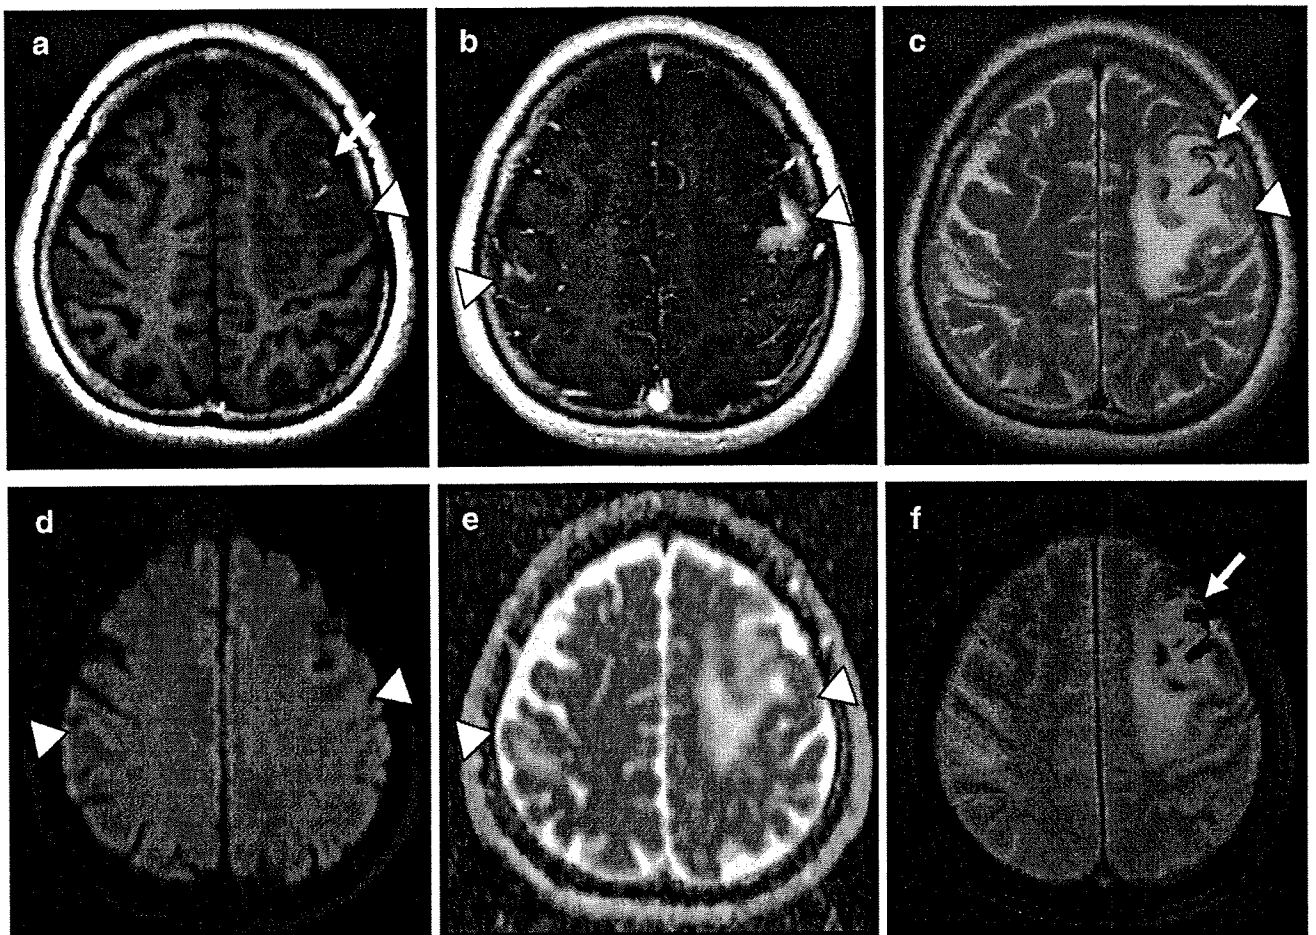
Cranial MRI of the lesions in left frontal lobe and right postcentral gyrus. The right side is shown on the left-hand side of each figure. a. Axial T1-weighted image demonstrates a hypointense area with focal hyperintensity (arrows) in the left frontal cortex and a small hypointense area in the right postcentral cortex. These lesions were surrounded by white matter edema that appeared homogeneously hypointense on T1-weighted images. b. Axial gadolinium-enhanced T1-weighted image shows focal enhancement of the cortical lesions in both hemispheres. c. Axial T2-weighted image shows slightly hyperintense area with focal hypointensity (arrows) in the left frontal cortex, and a slightly hyperintense area of the right postcentral gyrus. These lesions were surrounded by white matter edema that appeared homogeneously hyperintense on T2-weighted images. d, e. All lesions show high signal intensity on diffusion-weighted image (DWI) and slight low ADC values, while peripheral edema is slightly hypointense on DWI with elevated ADC values. f. Axial gradient-echo T2*-weighted image demonstrated hypointensity of the cortical laminar hemorrhage in the left frontal cortex (arrows).
